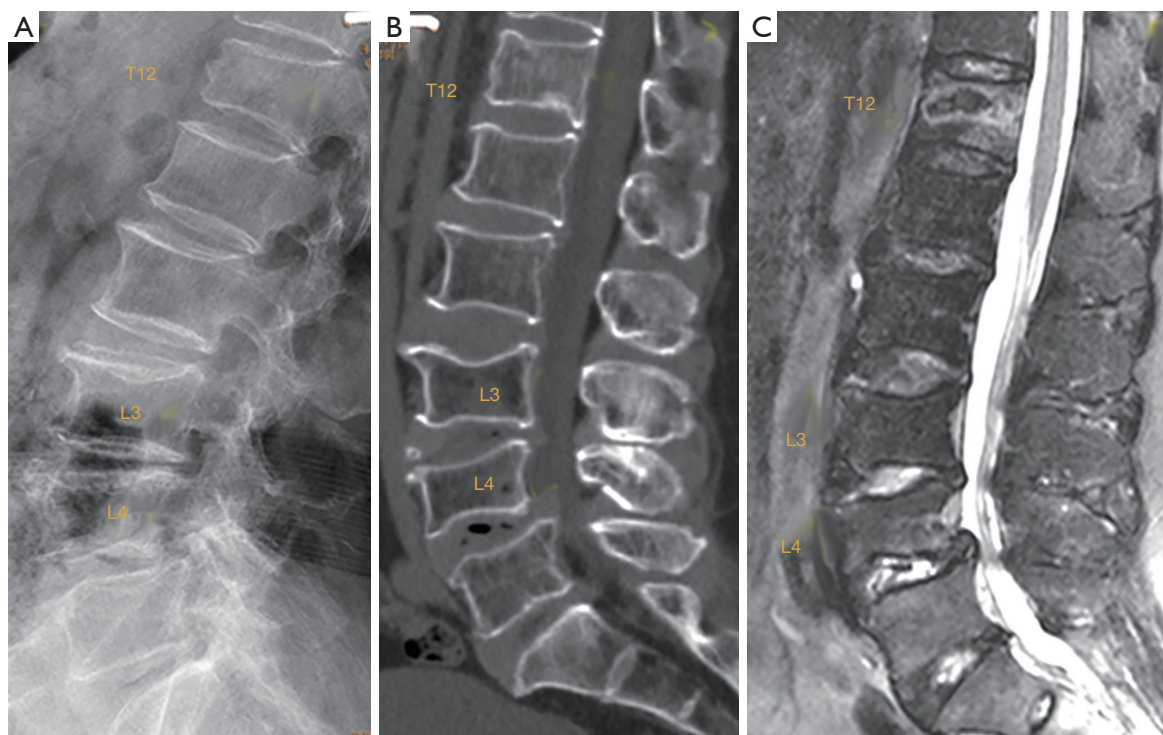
Elderly patient with spine trauma. (A) Radiograph; (B) sagittally reconstructed CT; (C) sagittal T2 weighted fat suppressed MRI. A T12 traumatic fracture, L3 chronic osteoporotic upper endplate fracture, and L4 chronic osteoporotic deformity (i.e., fracture) are detected. For T12, on radiograph, attention should be paid to the anterior cortex fracture and vertebral height loss, while on MRI apparent abnormal high signal is noted. Conversely, L3 and L4 show deformity, but no abnormal high signal is noted on MRI. CT, computed tomography; MRI, magnetic resonance imaging.
